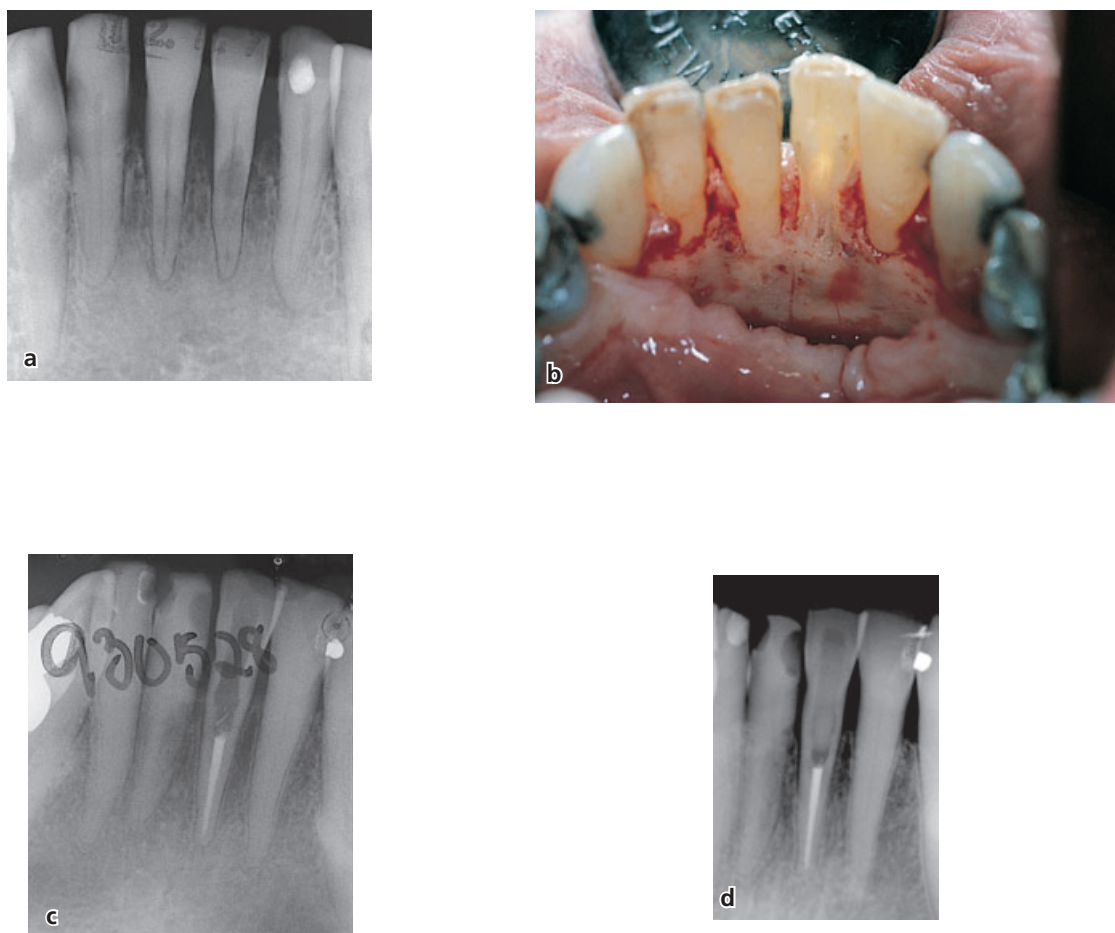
Case with external root resorption on the lingual aspect of both central incisors. (a) The patient, a 78-year-old lady, had presented herself to the clinic after an episode of severe pain and development of a lingual periodontal abscess. The medical history was unremarkable. The patient was initially managed by antibiotic treatment. (b) Later, upon flap elevation and accessing the resorbing area and removal of the granulation tissue, exposure to a necrotic pulp of tooth #31 was noted. (c) Endodontic treatment was carried out during the surgery procedure. Tooth #41 was left without any further treatment and the case was followed clinically and radiographically. No recurrence of resorption occurred on either tooth and the patient remained comfortable. (d) Radiograph of the last follow-up is 8 years after treatment. Note that there is no progression of the resorptive process associated with tooth #41.
